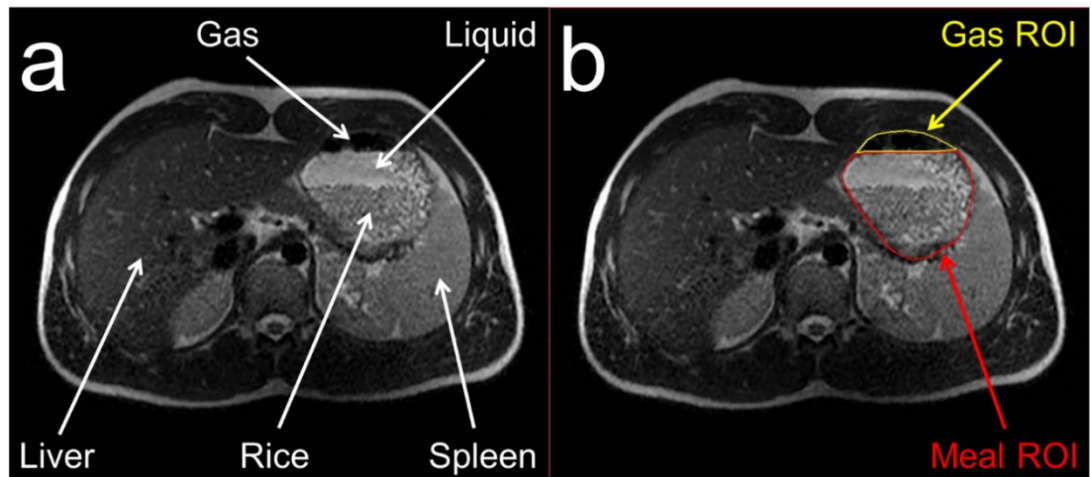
(a) Representative axial MRI image of the rice meal and water drink inside the stomach of a participant taken at T=15 minutes. (b) shows the same image but with regions of interest (ROIs) drawn over the stomach gas and stomach meal using the MIPAV software. Anatomical landmarks such as the liver and spleen are also indicated by white arrows for ease of orientation.
